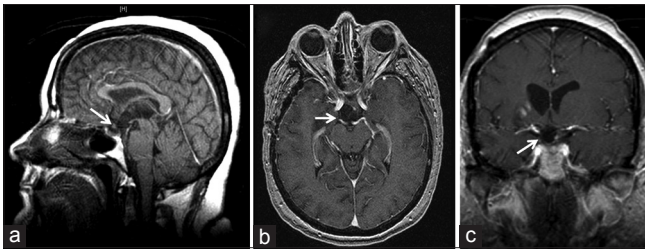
Postoperative MRI studies. (a) Midsagittal T1-weighted MRI scan after total removal of this intrachiasmatic craniopharyngioma. The outline of the prefixed, downward displaced optic chiasm (white arrow) is observed next to the defective or “breached” third ventricle floor, as the atrophic tuber cinereum was removed along with the tumor. (b, c) Axial and coronal T1-weighted scans through the level of the optic apparatus. Notice the anatomical injury to the optic chiasm-right optic tract junction after removing the lesion (white arrows)
